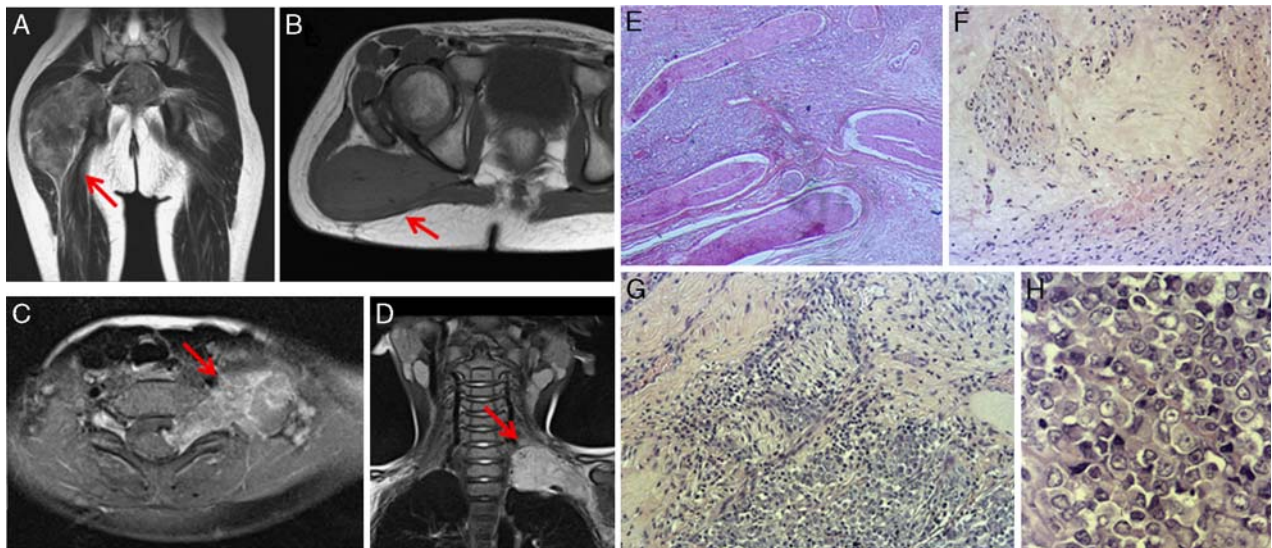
PNS tumors mimicking MPNST. MRI examination of patient 7: (A) coronal T2-WI and (B) axial T1-WI show a well-circumscribed lesion ($7 \times 4 \times 8$ cm) displacing gluteus maximus muscle arising from the sciatic nerve. The tumor (arrows) appears as a solid mass with isosignal on T1-WI as compared with muscles and heterogenous overall high signal intensity on T2-WI with nodular low signal intensities. MRI examination of patient 2: (C) postcontrast axial T1-WI and (D) coronal T2-WI show a solid dumbbell mass originating from the left C7-T1 foramen (spinal nerve and brachial plexus roots). The tumor (arrows) appears as a solid well-circumscribed mass ($3 \times 6.5 \times 2$ cm) with heterogenous overall high signal intensity on T2-WI with nodular high signal intensities and heterogeneous enhancement after contrast media injection. Case 9: (E) coexistence in the same tumor of rhabdoid cell components and structurally hyperplastic and disorganized nervous structures characterized by different orientations of the fibers, both longitudinal and transverse, evoking the common findings of a benign nerve tumor that is neurofibroma-like. Case 2: (F) benign nervous component, showing obviously abnormal proliferation and organization of Schwann cells and fibrosis, resembling neurofibroma; (G) transition zone with intermixed rhabdoid component and benign nervous proliferation; (H) rhabdoid component. WI indicates weighted image.
